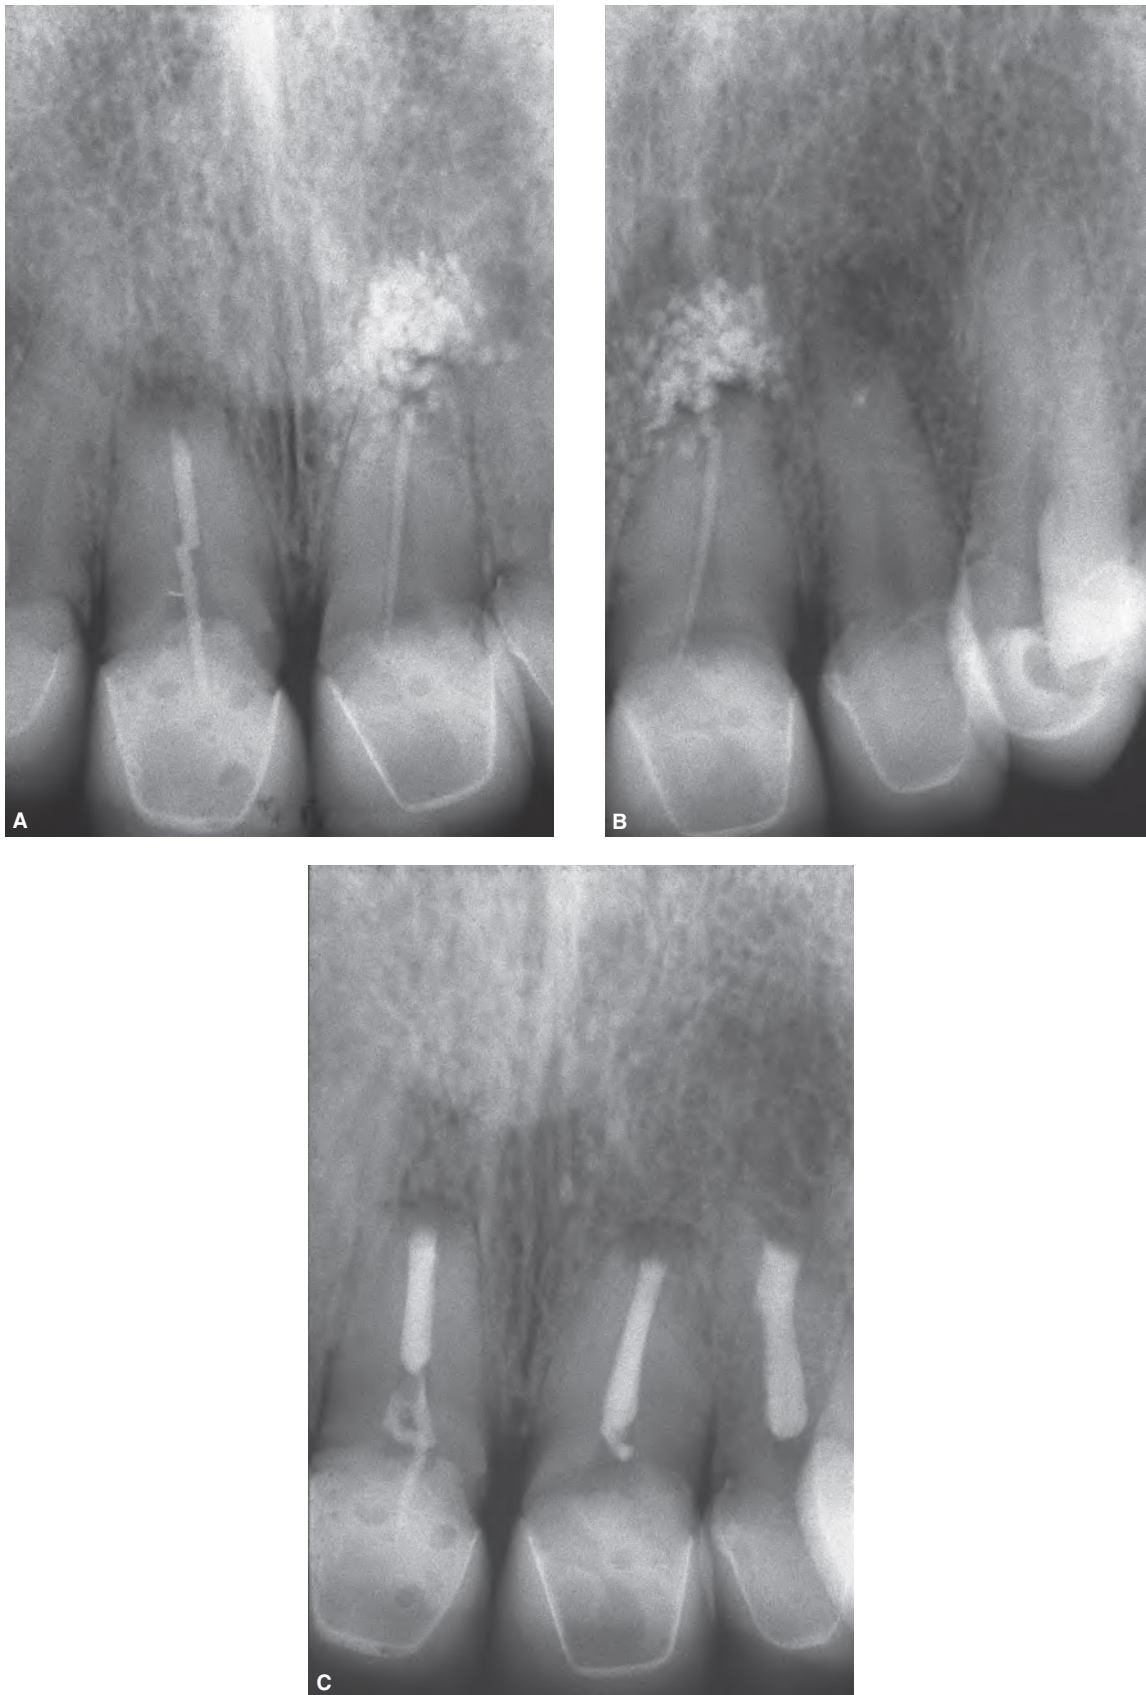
A,B*, Preoperative radiographs of the maxillary central incisors and the left lateral incisor. Surgical endodontic treatment was done. The thermoplastic gutta-percha was introduced to each root canal during the surgical procedure, before root-end filling with white-color MTA. *C*, Seven-month recall radiograph.
